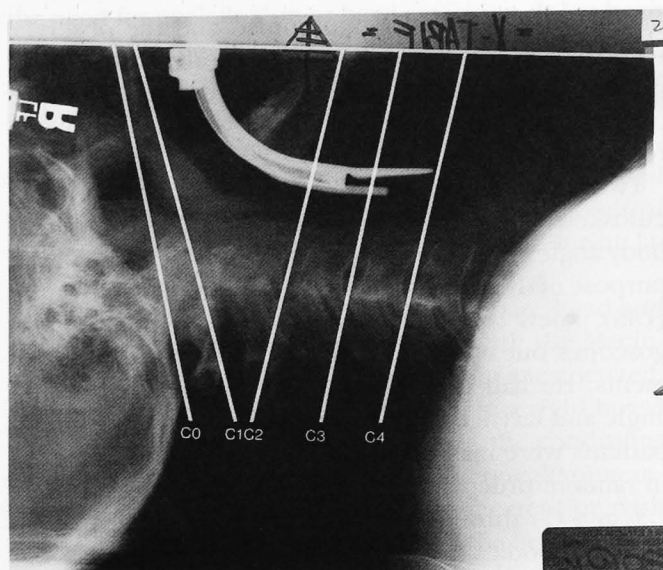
Sample radiograph displaying reference lines for each vertebral level: Occiput (C0), through caudal posterior portion of occiput and hard palate; C1, tangent between the anterior and posterior arch of the atlas; and C2, C3, and C4, through posterior and anterior basal plate of the respective vertebral bodies. Laryngoscopy is performed with the Bullard laryngoscope. The reference lines for adjacent levels, except for C1 and C2, are nearly parallel and do not intersect on the radiograph. Therefore, angles were measured with a goniometer between the reference lines and a common line, the upper horizontal edge of the radiograph. Angles between adjacent levels were calculated by difference. For example, C1-C2 angle = (C1 to common line angle) - (C2 to common line angle). Positive angles denoted extension, and negative angles denoted flexion. The other measurement made on these radiographs was the distance from the anterior margin of the C4 vertebral body, at its midpoint, to the tip of the Bullard or Macintosh laryngoscope blade. The intubating stylet of the Bullard laryngoscope lies approximately 1 cm below the blade extender. The light carrier and fiberoptic bundle lie between the stylet and the blade extender, approximately 2 cm proximal to the end of the stylet.
